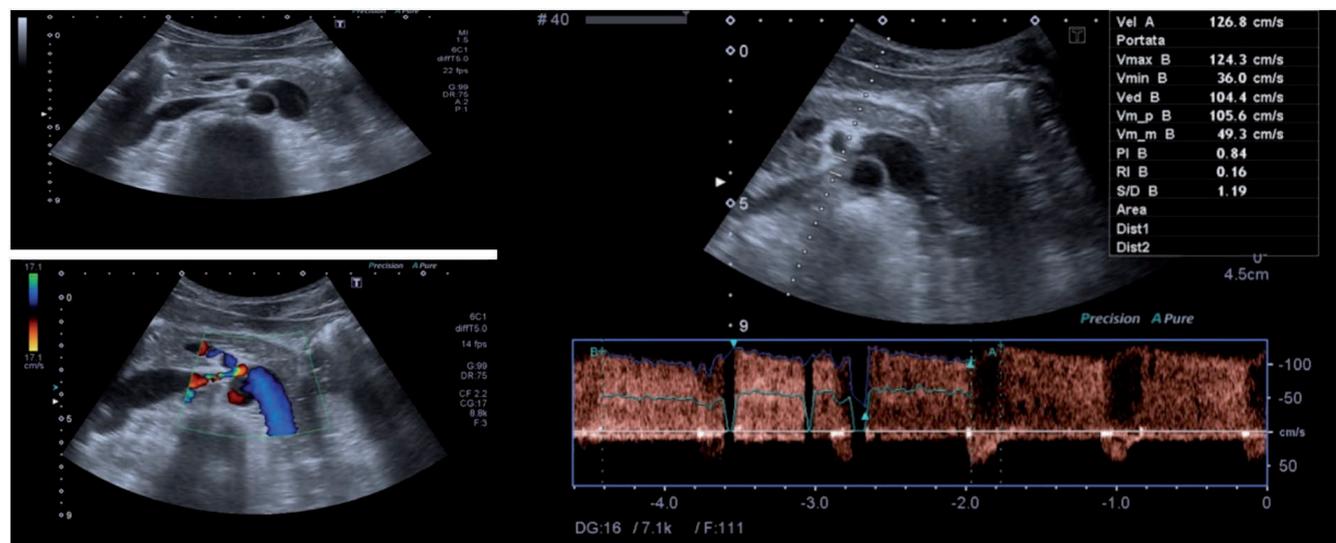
Doppler ultrasound images of patient 1 showing the LRV stenosis due to compression by the SMA and peak velocities.
